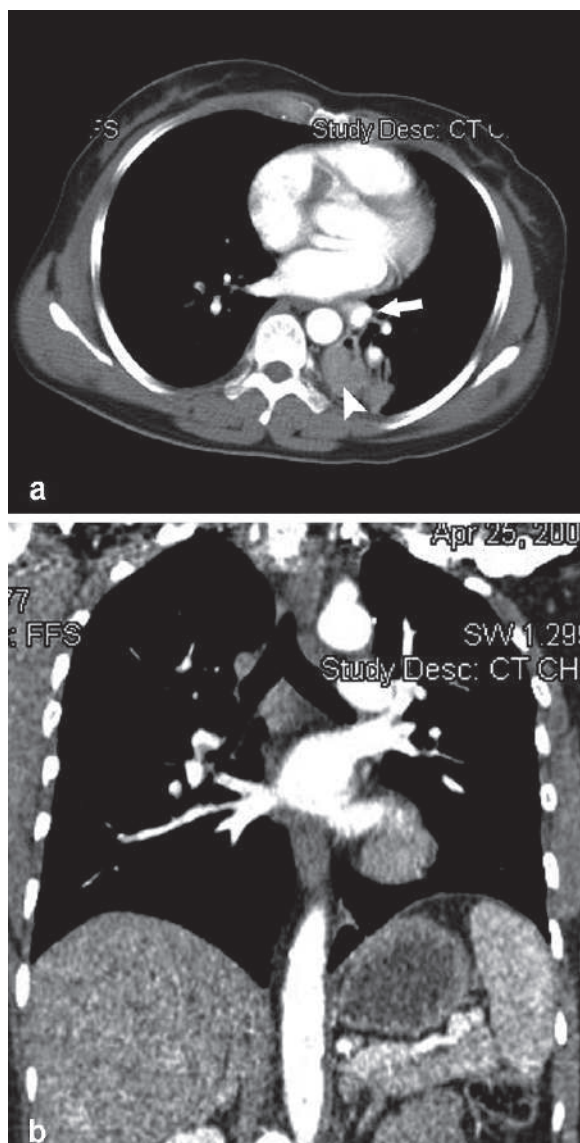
Axial (a) and coronal (b) chest CT shows left lower lobe intralobar bronchopulmonary sequestration mass (arrowheads) with its abnormal arterial supply arising from the descending thoracic aorta (arrows)
